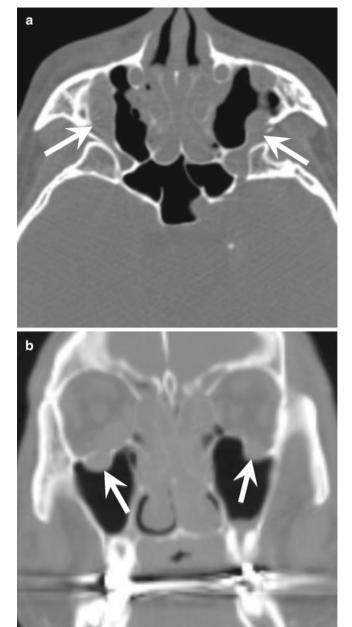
Same case as in Fig. 18.2. (a) CT axial section and (b) coronal section. Enlargement of the bilateral infraorbital canals is found, but no osteoclastic changes are evident
